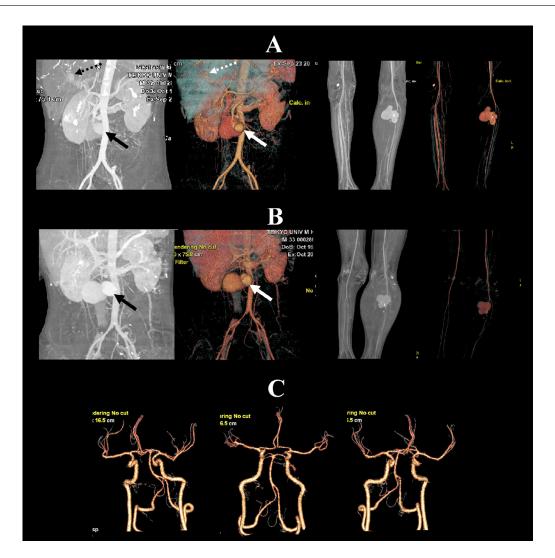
3D-CT angiography. (A) Three weeks after admission: 3D-CT angiography image showing pseudoaneurysms in the hepatic (dotted arrows), superior mesenteric (arrows), and left popliteal arteries. The pseudoaneurysm in the left popliteal artery is extremely large, being 6 cm in diameter. (B) Seven weeks after admission. The pseudoaneurysm in the hepatic artery is no longer apparent, whereas those in the superior mesenteric and popliteal arteries are still present. The diameter of the popliteal pseudoaneurysm has decreased; however, the left lower leg is enlarged, suggesting bleeding into the left calf. (C) Intracranial 3D-CT angiography. No intracranial pseudoaneurysms are identifiable on 3D-CT angiography.
